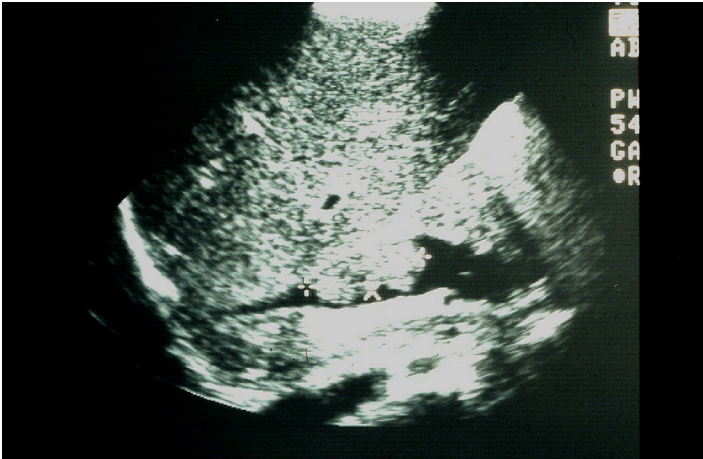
Ultrasound of the inferior vena cava in a child with Wilms' tumor with tumor extension into the renal vein. Note the tumor mass (markers) within the vena cava.
